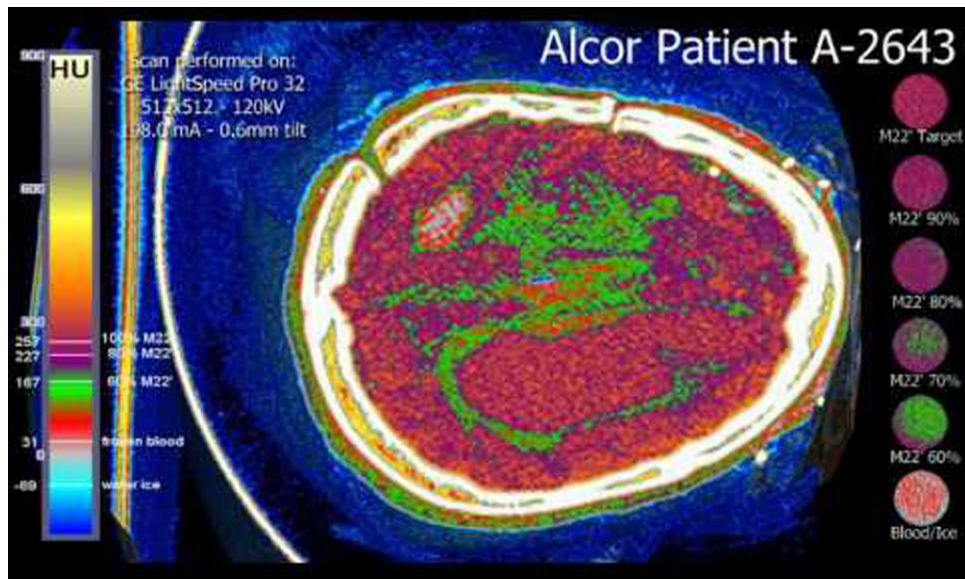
A CT scan of the cryopreserved brain of an Alcor patient.
